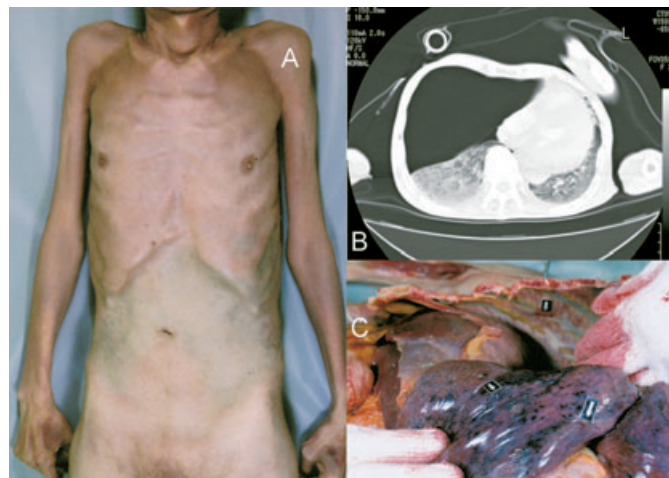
A case of traumatic tension pneumothorax. An 88-year-old man was found lifeless at home by his family. He was recently predisposed to easily falling down. Inquest showed no overt damage on the external surface. Police suspected no foul play, and the doctor who witnessed the inquest also determined that the patient likely died from disease. A computed tomography scan in our department showed a tension pneumothorax in the chest (B) and rib fractures. The subsequent autopsy found the rib fractures and the associated pulmonary contusion (C) despite no apparent damage on the surface (A).
